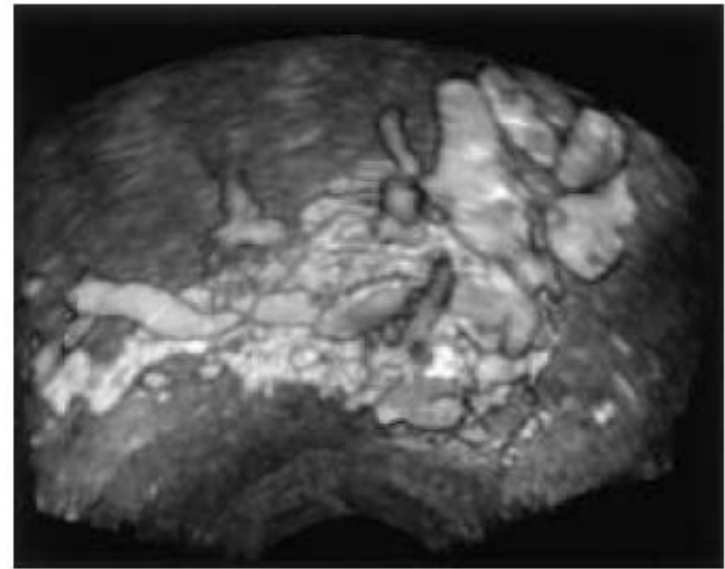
Three-dimensional power Doppler ultrasound demonstrating a viable pregnancy with irregular course and branching peritrophoblastic vascularity in the myometrium of the anterior uterine wall.
